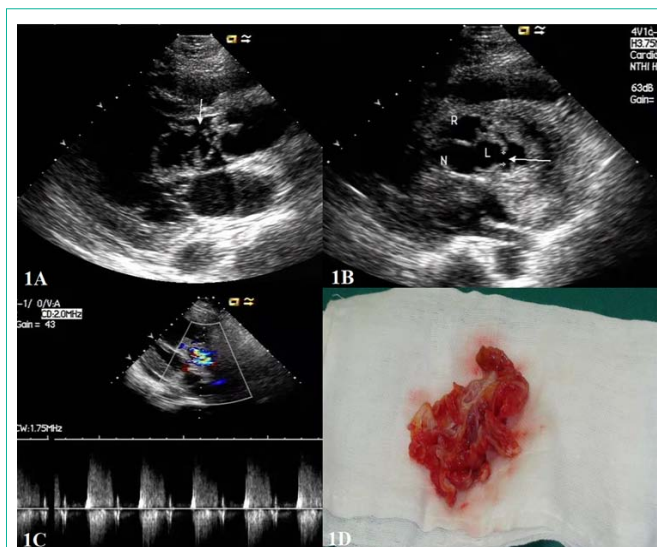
A: left ventricular long-axis view showed the saccular structure (SVA) in LVOT and the breach on the side of the ventricular septum; B: short-axis view of the aorta showed the entrance diameter of the saccular structure (SVA) is about 6mm; C: the multicolored blood flow signal flows from the saccular structure to LVOT, and its blood flow velocity was about 4m/s as measured by spectral Doppler; D: ruptured aortic sinus removed during surgery.
